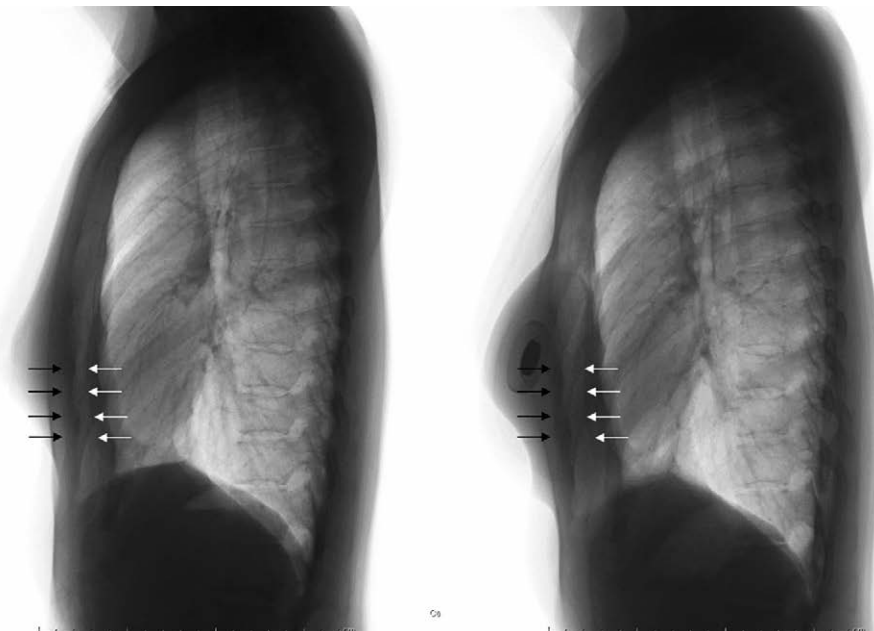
A lateral chest x-ray image of the patient. The left-hand side shows the preoperative image, and the right-hand side shows the postoperative image with a breast expander. White arrows indicate the chest wall of the right side, surgery site, and black arrows indicate the chest wall of the left side, non-surgical site. A distance between white and black arrows became wider after the placement of a breast expander.
